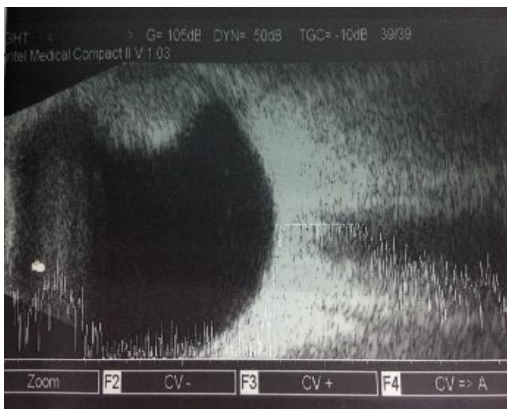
Right eye B scan ultrasonography of the right eye showed a mushroom-shaped intraocular mass.
